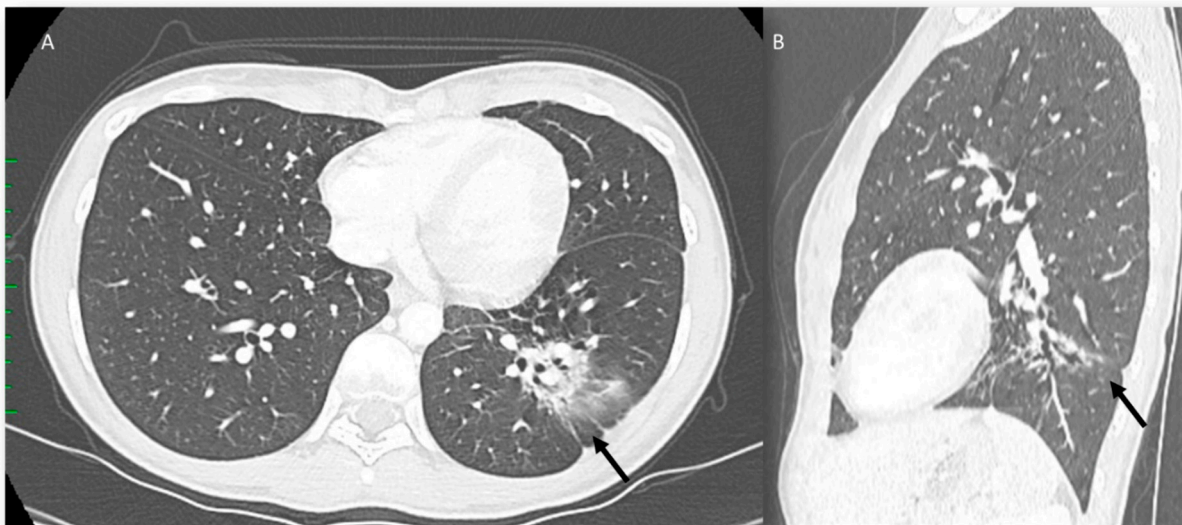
CT assessment ((A): axial plane) of RRP (arrow) in radio-treated melanoma metastasis during ICI therapy; resolved ((B): CT in sagittal plane) after steroid therapy (arrow).
